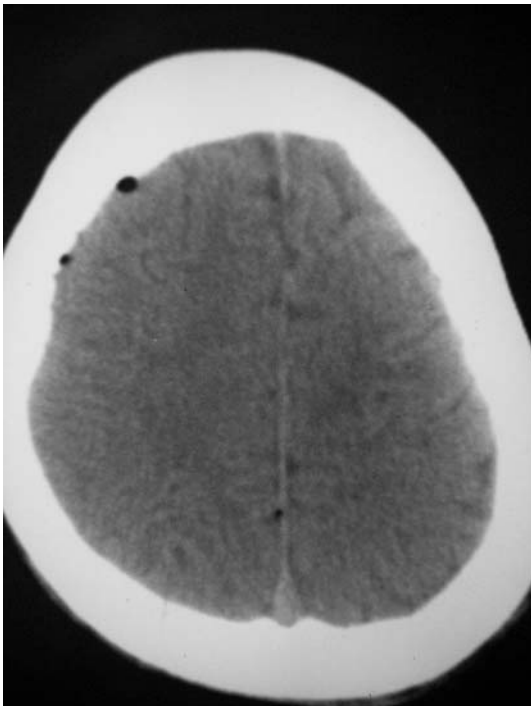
Cranial CT has nearly normal appearance after the end of the third week of treatment
